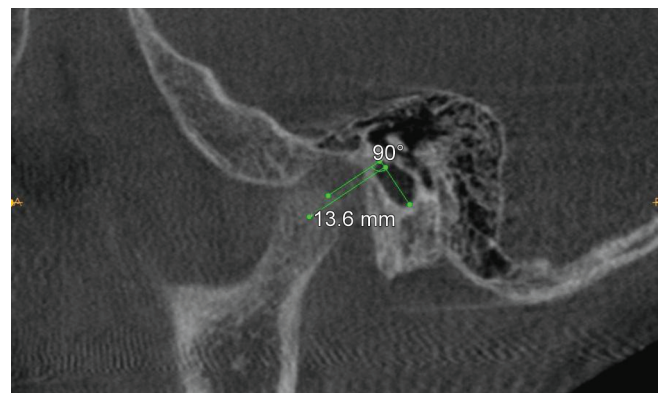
Cone-beam computed tomography (CBCT) scan of condylar position posttreatment
